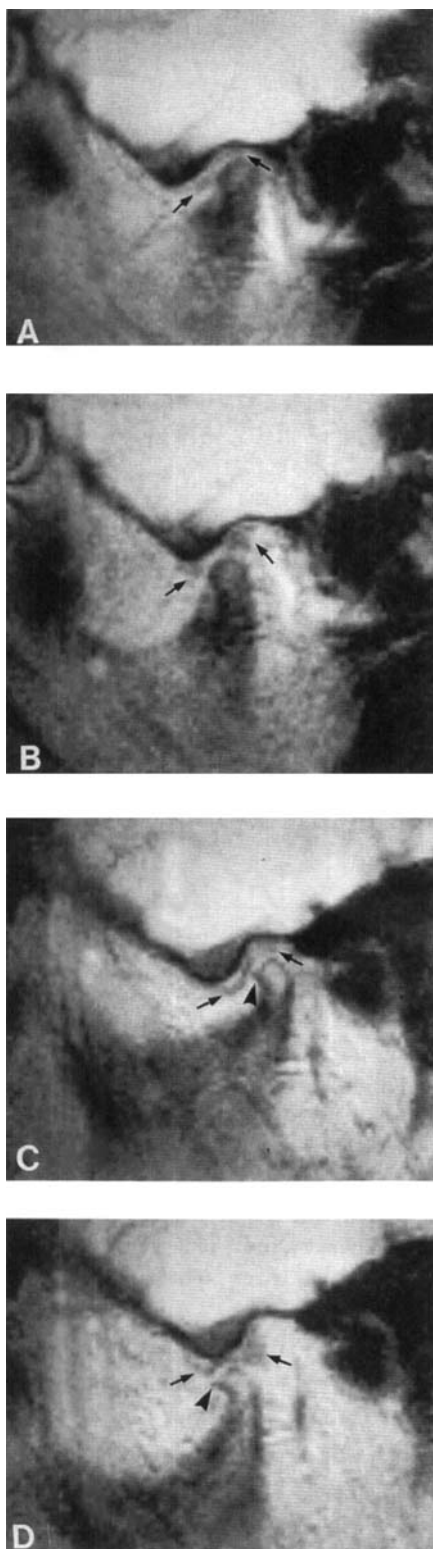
Sagittal gradient echo MRI images of the TMJs (TR 280 ms, TE 15 ms, flip angle 40°, 4 mm thick slices). A: The right TMJ at mouth closed and open (B) positions. The movement of the mandibular condyle is strongly restricted. The biconcave disc is seen at a normal position between articular surfaces (arrows). C: The left TMJ at mouth closed and open (D) positions. The disc is at normal position between articular surfaces (arrows). A small anterior osteophyte is distinguishable on the condylar head (arrowhead). The movement of the mandibular condyle is slightly restricted (D).
